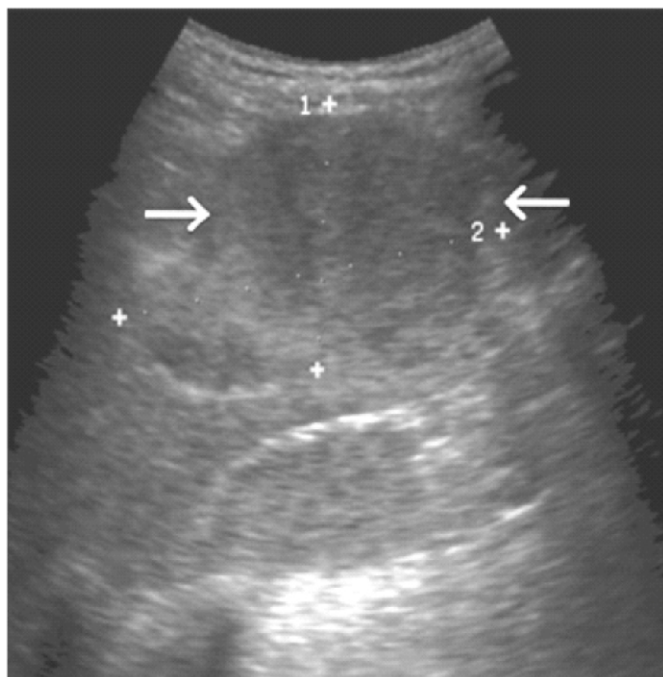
Ultrasonography of a case of hepatocellular carcinoma
